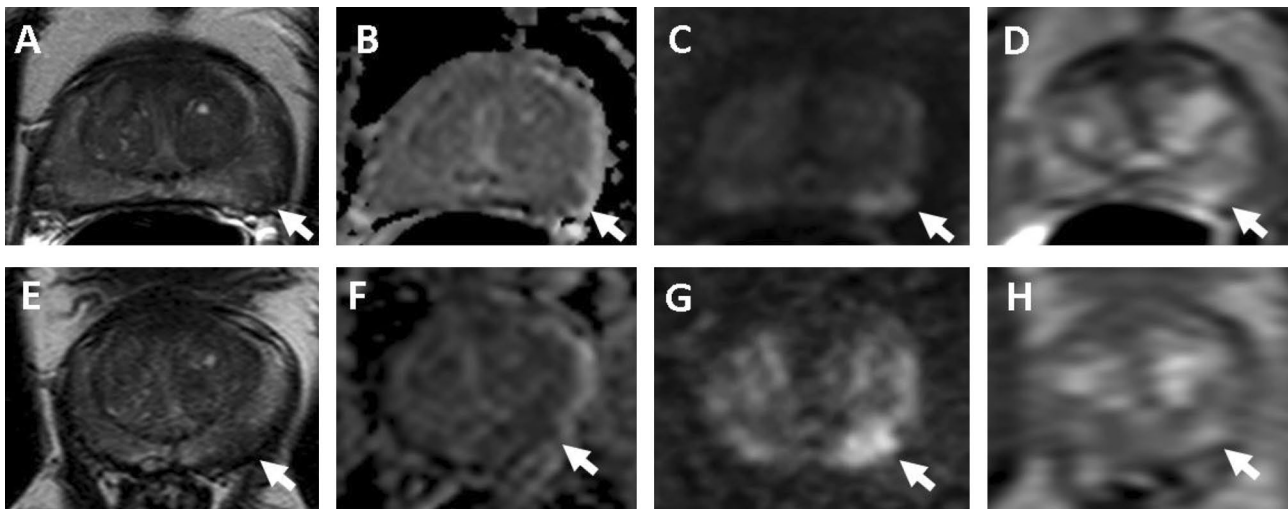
63-year-old man with a PSA=4.7 ng/ml. Multi-parametric MRI obtained with combined use of an endorectal coil including axial T2W MRI (a), ADC map of DW-MRI (b), b2000 s/mm² DW-MRI (c) and DCE MRI (d) shows a lesion in the left mid-peripheral zone (arrows). The same patient underwent a multi-parametric MRI
